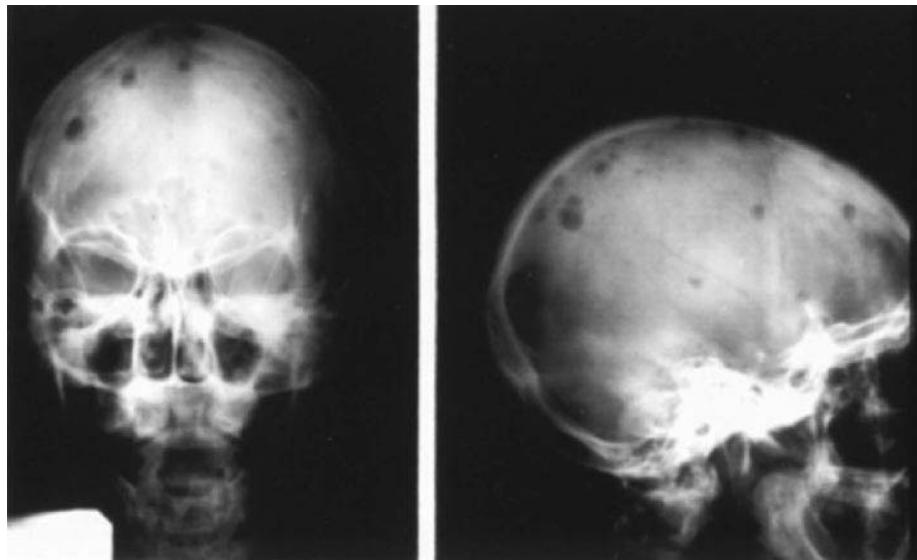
X-ray of the skull of a patient with multiple myeloma showing typical osteolytic lesions. (Courtesy of Dr. S. Richardson.)
